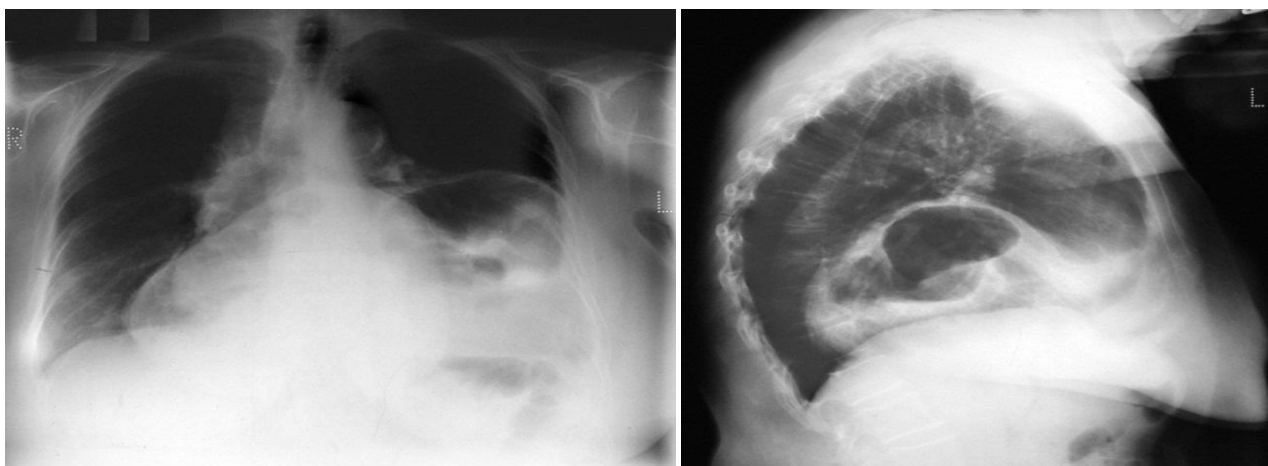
Frontal and lateral Chest Radiograph in patient with large hiatal hernia demonstrating retro-cardiac opacity with radiolucent gas, which shifts mediastinum to the right. [Source internet site : emedicine.medscape.com](http://www.emedicine.medscape.com)
